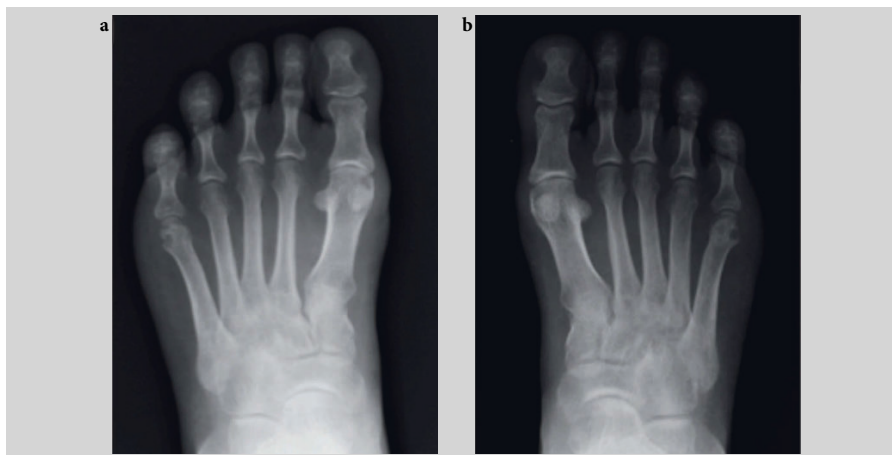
Early erosive rheumatoid arthritis of the feet. Posteroanterior radiographs demonstrate erosions of the fifth metatarsal heads bilaterally and symmetrically (a and b). There is diffuse inflammatory joint space narrowing of the first and fifth metatarsophalangeal joints. Although these erosions do appear corticated in places, they are not to be confused with gouty lesions since other signs in the feet (joint space narrowing elsewhere) are more consistent with rheumatoid arthritis.
